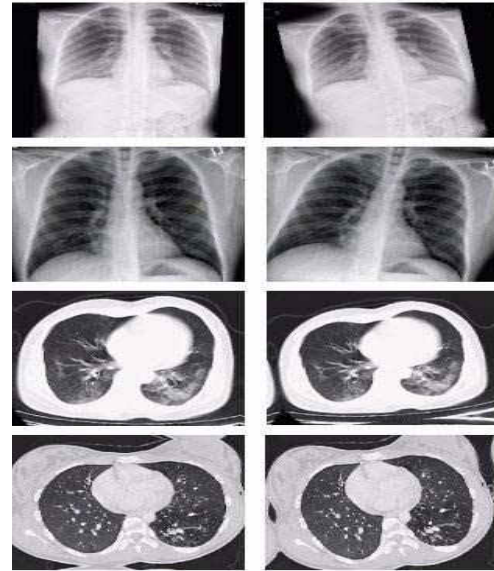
CT and CXR results after Image augmentation.
